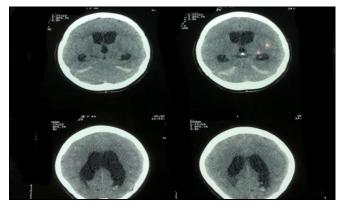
CT-Brain showing Intracranial Bleed (Subarachnoid Hemorrhage) and Communicating Hydrocephalus
